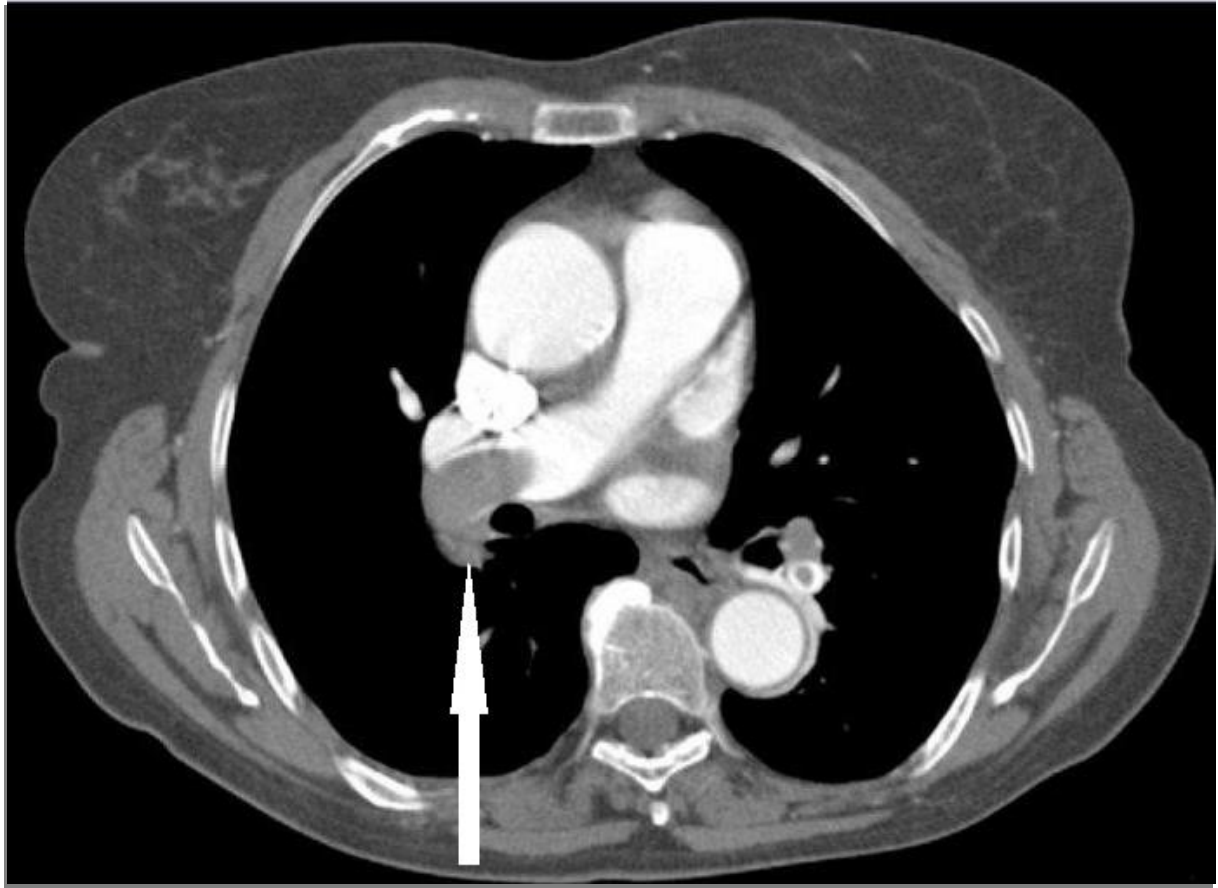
A58 year's female axial CT image of the chest demonstrating acute massive pulmonary embolism in the right main pulmonary artery.
